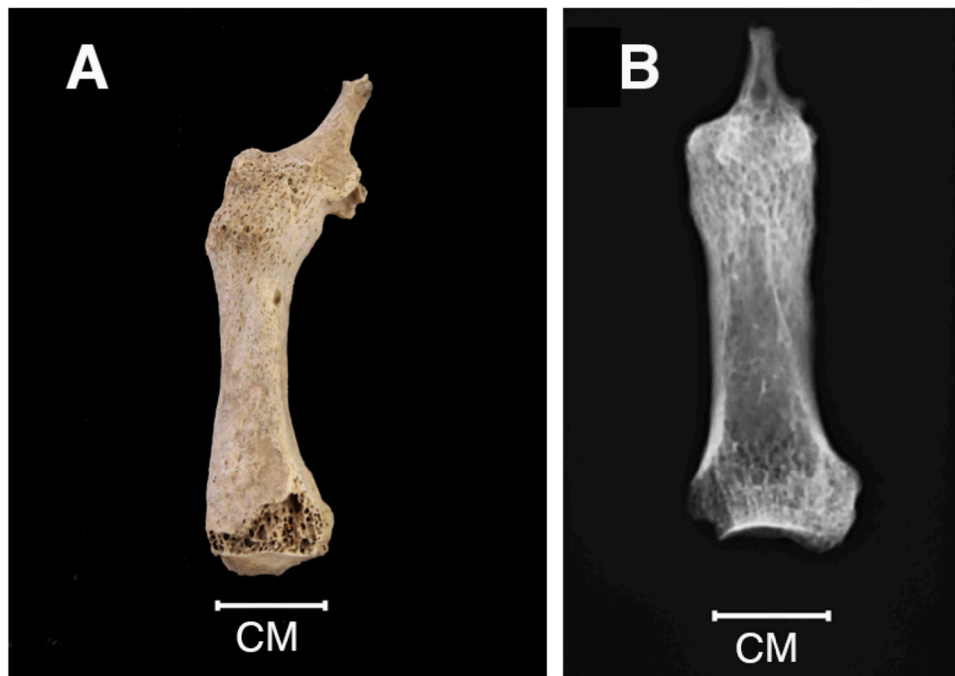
A) Acro-osteolysis of the second intermediate phalanx and fusion with the second proximal phalanx of the left hand of individual UF 104 UE 56 (female, indeterminate age at death). Medial view. B) Coronal view radiograph of the left second intermediate and proximal phalanx.
